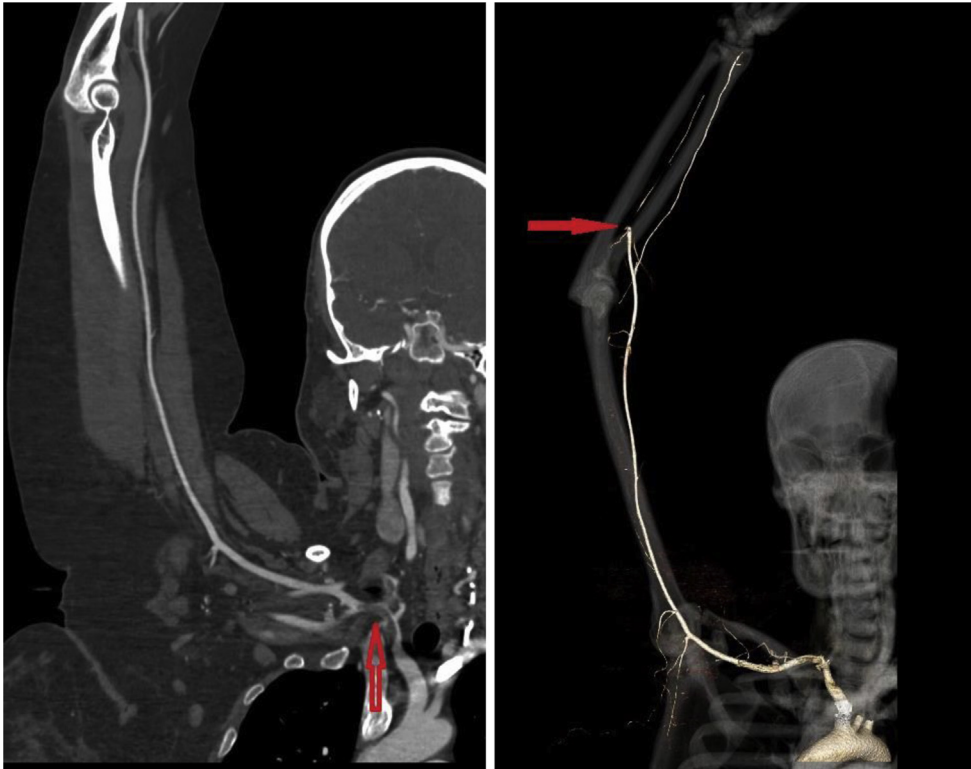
Multifocal vascular occlusions. Computed tomography angiogram of the right upper extremity demonstrating a large thrombus in the proximal right subclavian artery immediately distal to the origin of the common carotid artery (*left*), as well as complete occlusion of the right ulnar artery in the antecubital fossa and extending to the hand (*right*).
